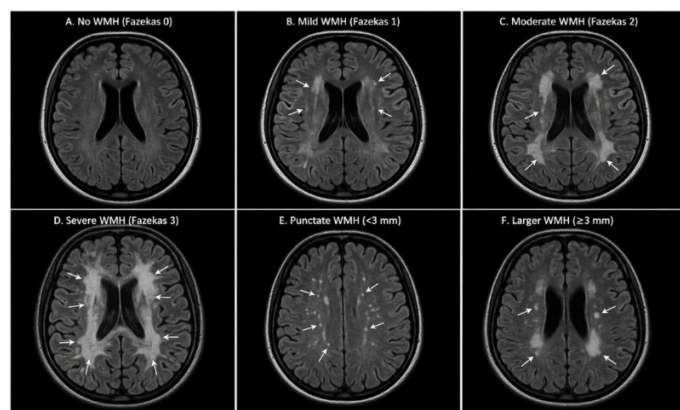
Representative axial fluid-attenuated inversion recovery (FLAIR) magnetic resonance imaging (MRI) images demonstrating white matter hyperintensities (WMHs) in patients with migraine. (A). No WMHs (Fazekas Grade 0). (B). Mild punctate deep white matter hyperintensities (Fazekas Grade 1). (C). Moderate white matter hyperintensities with early confluence of lesions (Fazekas Grade 2). (D). Severe confluent periventricular and deep white matter hyperintensities (Fazekas Grade 3). (E). Representative punctate WMHs measuring <3 mm. (F). Representative larger WMHs measuring ≥ 3 mm. White arrows indicate the representative WMHs.
